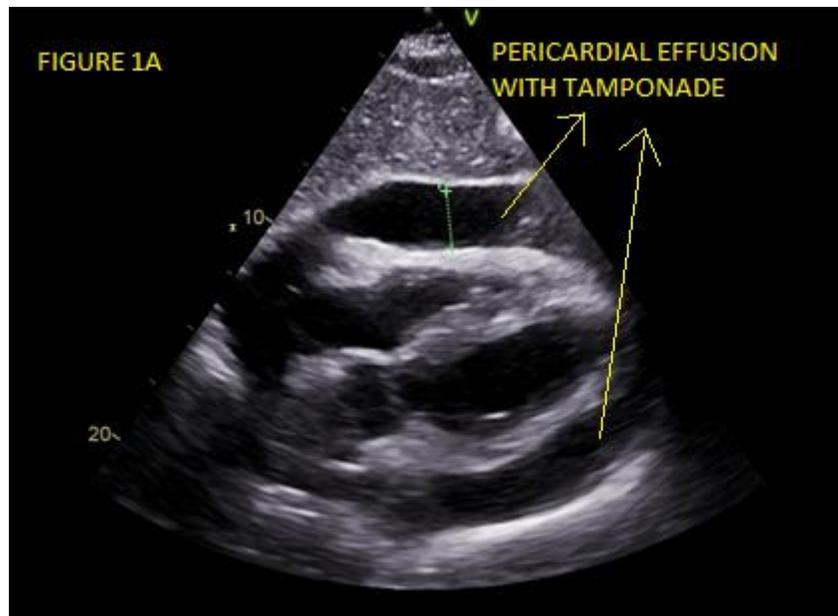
The 2D echocardiographic image shows a massive pericardial effusion.
